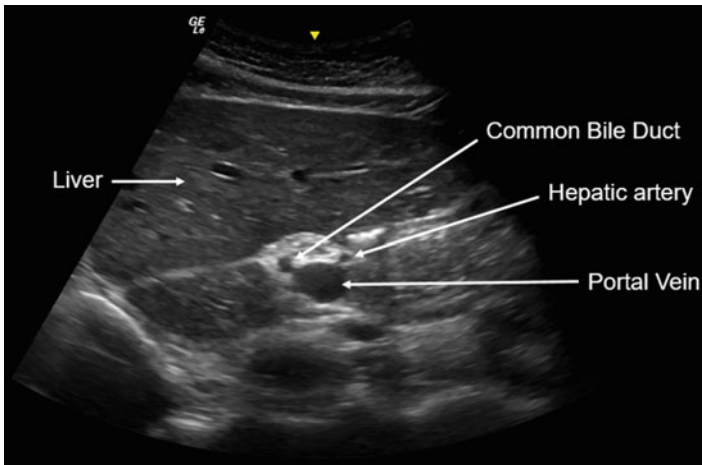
Ultrasound is useful in visualizing vascular structures and ducts. In this image, the hepatic artery, hepatic vein, and common bile duct can be seen
